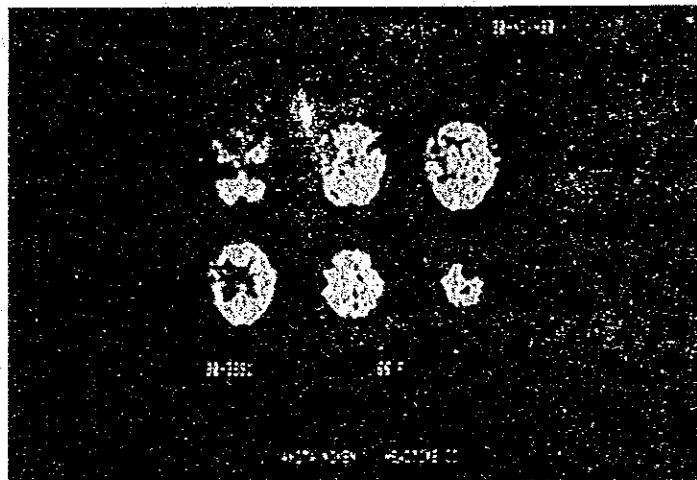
SPECT images using ^{99m}Tc -HM-PAO
